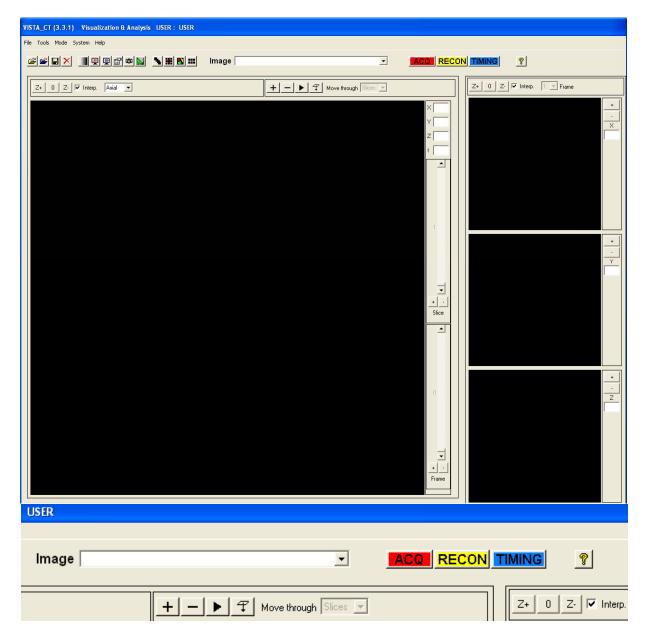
Main VISTA-CT interface (with a detail of the toolbar).
